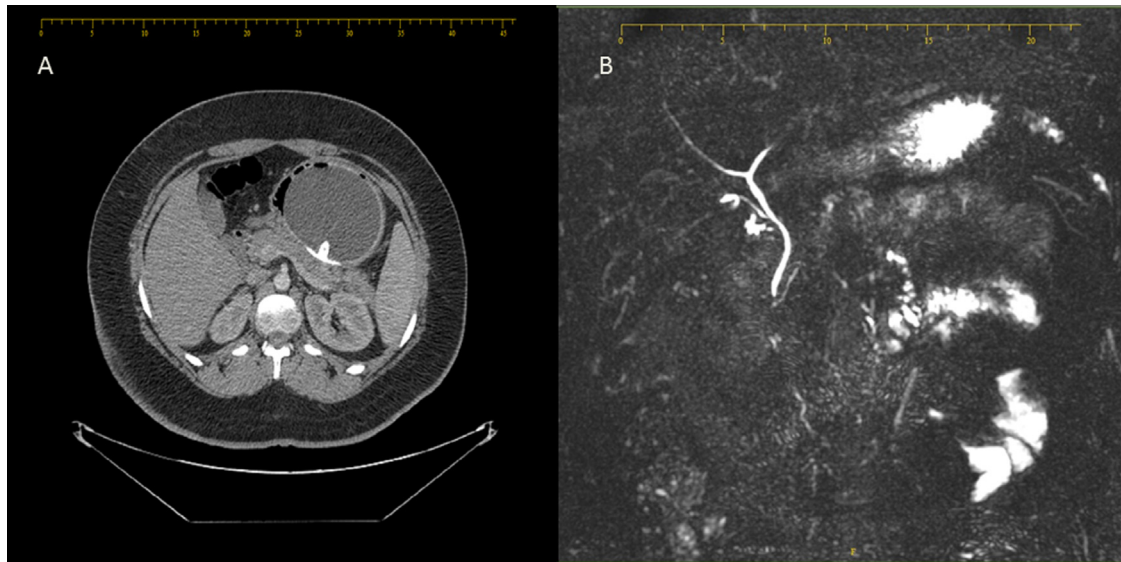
(A) Computed tomography scan showing the intragastric balloon compressing on the pancreas. (B) Magnetic resonance cholangiopancreatography showing no abnormalities in both the pancreatic ducts and the biliary tree.
